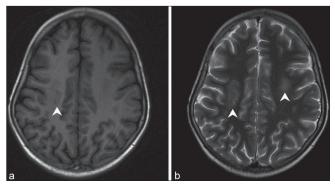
T1- (a) and T2-weighted images (b) from the follow-up study show subtle hypointensities (arrowhead in a) on the T1-weighted image with areas of hyperintensity of T2-weighted image (b)
